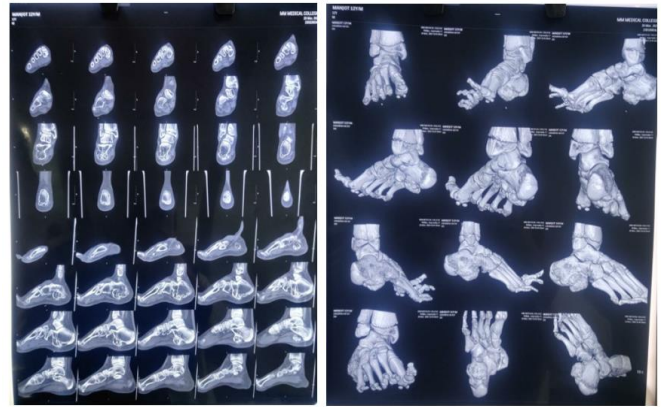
MRI and CT images showing a lesion over the plantar aspect of right calcaneum
